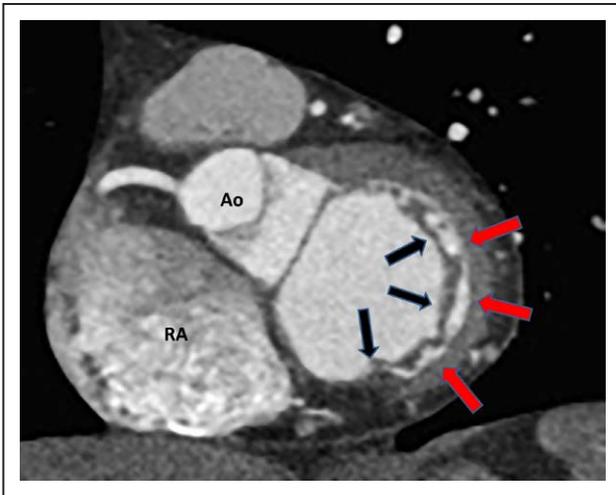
Computed tomographic analysis of mitral annulus. En face view (obtained by reorientation of the 3-dimensional imaging plane) of the mitral annulus and the valvular line of coaptation. Black arrows indicate mitral leaflets coaptation line, and red arrows indicate mitral annulus. Ao indicates aortic valve; and RA, right atrium.
